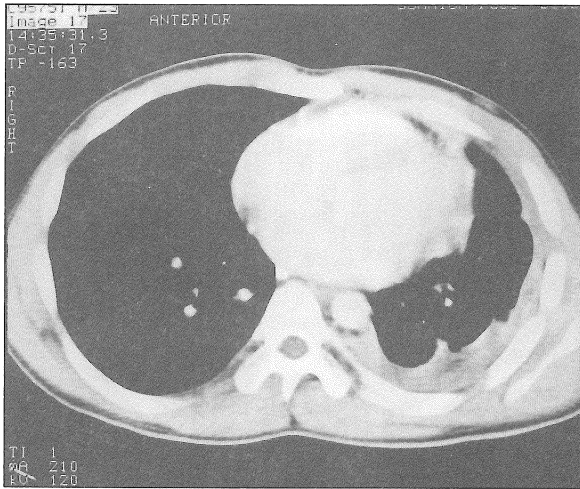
Chest CT scan of patient 5 showing left posterior basal pleural thickening
